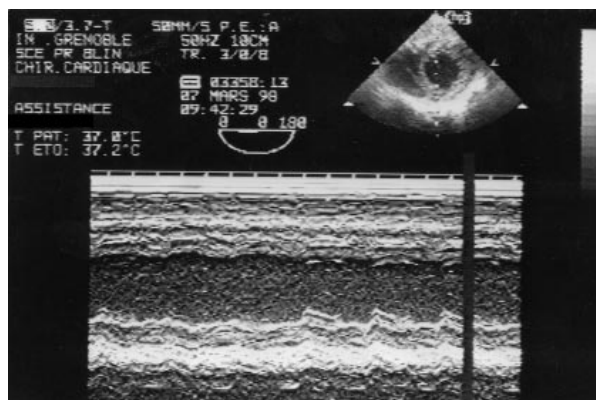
Transesophageal echocardiogram (short-axis view and M-mode echocardiogram) before implantation of LVAD shows severe diffuse hypokinesia of left ventricle and dilation of right ventricle with good contractility.
